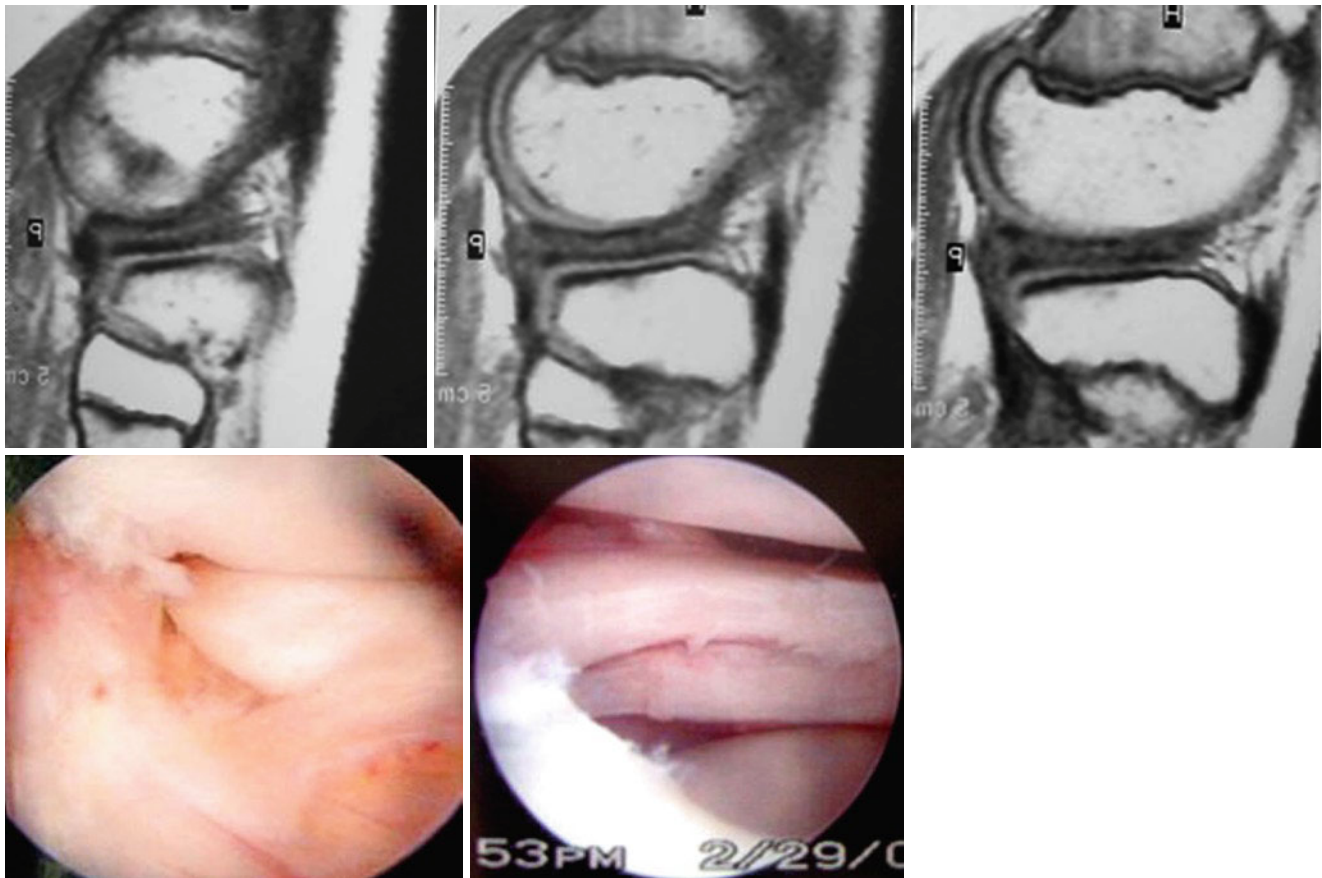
MRI and arthroscopic views of a horizontal tear of a discoid lateral meniscus
